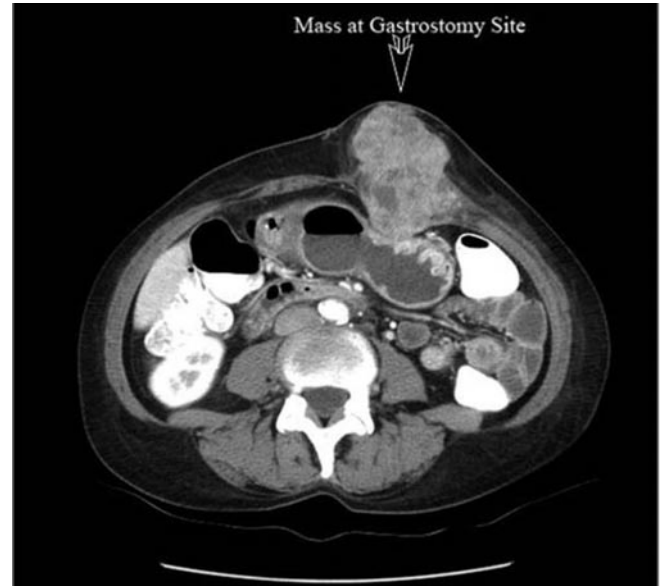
CT scan of another patient revealing mass infiltration from the stoma site into the abdominal and gastric walls.²⁷
